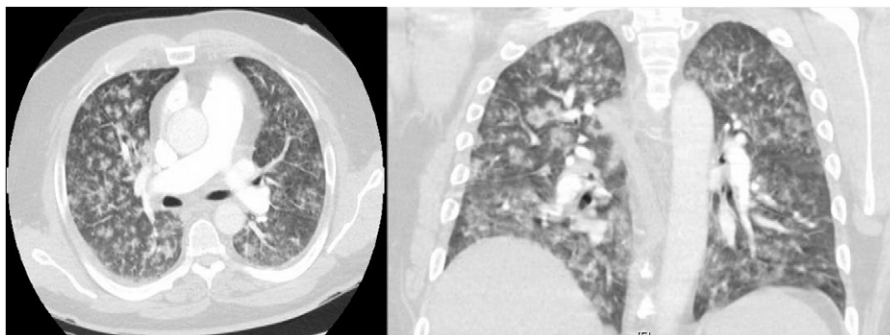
Chest computed tomographic scan showed extensive focal airspace opacities and the centrilobular nodular pattern giving an overall appearance not of “tree in bud” but of “tree in bloom.” (Left panel) Transverse plane. (Right panel) Coronal plane.
